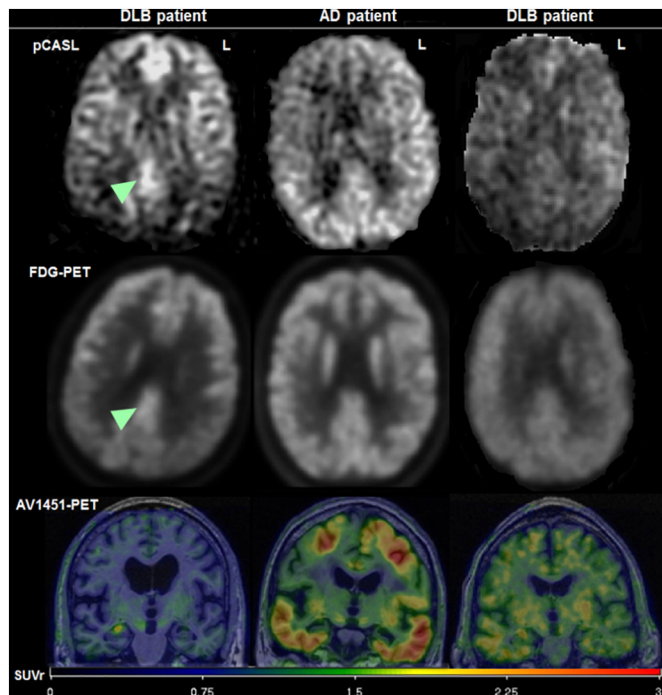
Individual imaging findings in DLB and AD patients. Left: a 70 years old male DLB patient who has visually preserved CIS on ASL and FDG-PET: the arrow head points to the relatively preserved perfusion in the posterior cingulate cortex, when compared to a lower signal in precuneus and cuneus. He has a minimal medial temporal AV-1451 uptake (the bright spot on the right side is a non-specific uptake in the choroid plexus and not in the hippocampus itself). Middle: A 74 years old male AD dementia patient who does not have visually preserved CIS on ASL or FDG-PET. He has a considerable AV-1451 uptake including the medial temporal cortex. Right: an 82 years old male DLB patient who does not have visually preserved CIS on either ASL or FDG-PET and he has higher medial temporal AV-1451 uptake than DLB patient to the left.
